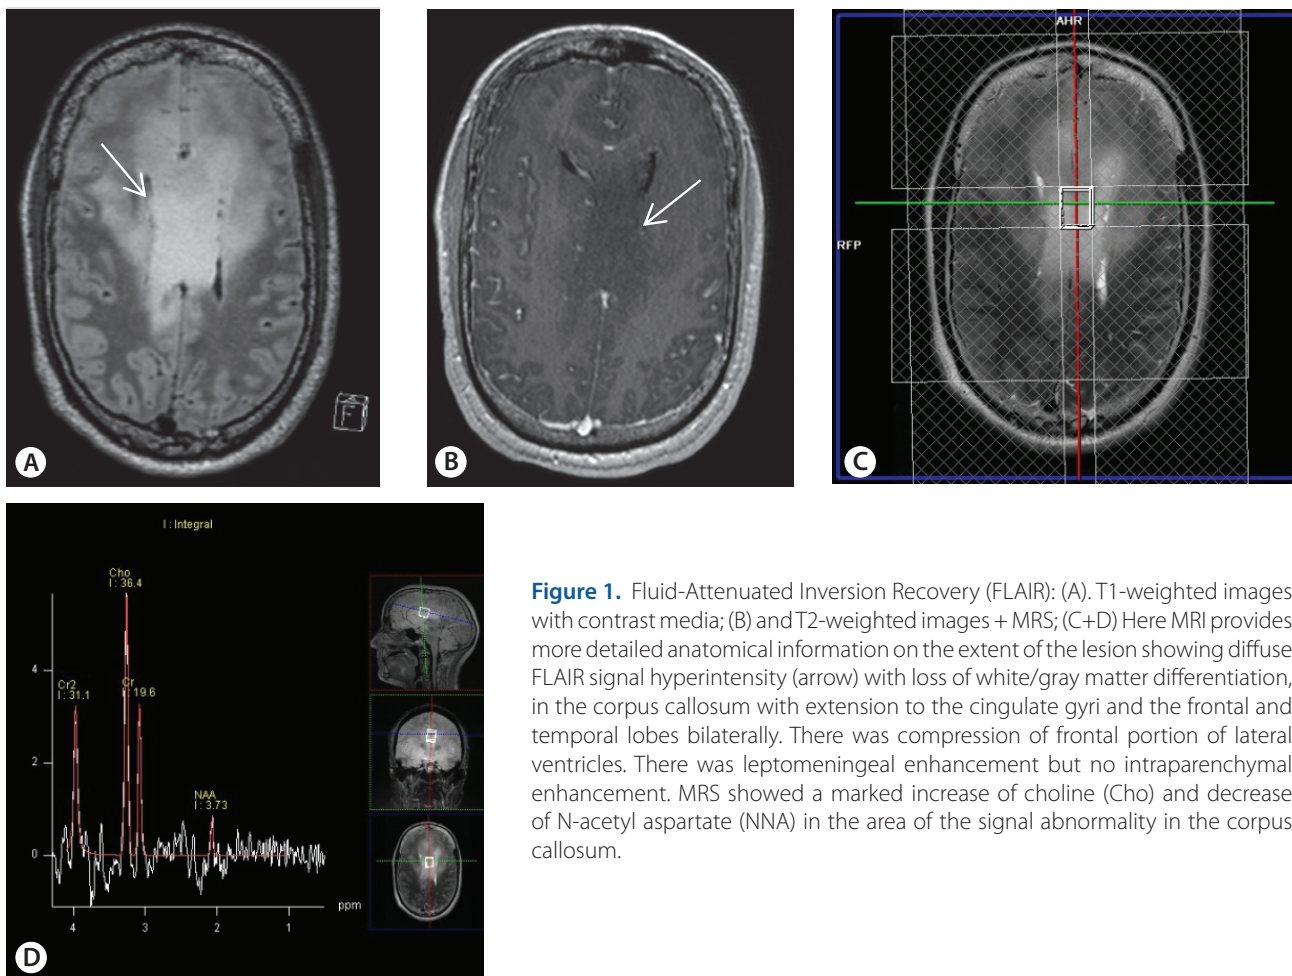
Fluid-Attenuated Inversion Recovery (FLAIR): (A). T1-weighted images with contrast media; (B) and T2-weighted images + MRS; (C+D) Here MRI provides more detailed anatomical information on the extent of the lesion showing diffuse FLAIR signal hyperintensity (arrow) with loss of white/gray matter differentiation, in the corpus callosum with extension to the cingulate gyri and the frontal and temporal lobes bilaterally. There was compression of frontal portion of lateral ventricles. There was leptomeningeal enhancement but no intraparenchymal enhancement. MRS showed a marked increase of choline (Cho) and decrease of N-acetyl aspartate (NNA) in the area of the signal abnormality in the corpus callosum.
